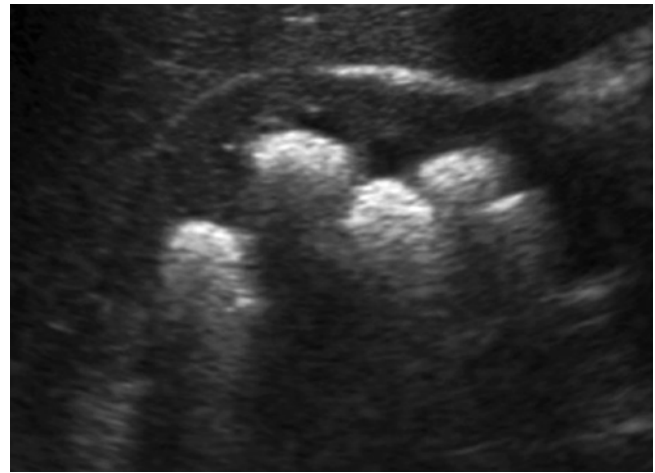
Greyscale ultrasound. Longitudinal scan. Staghorn renal stone with multiple hyperechogenicities with posterior acoustic shadowing in the renal pelvis
